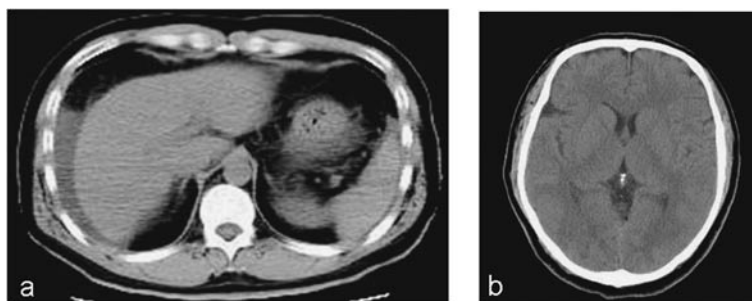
CT scan of case 1.
